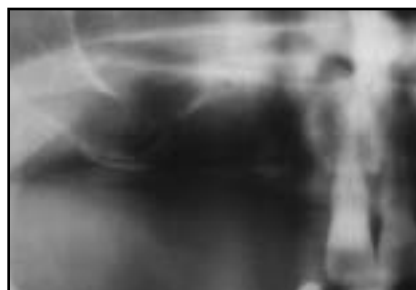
Orthopantomogram (patient VP) demonstrates vertical bone defect contiguous to maxillary sinus.
